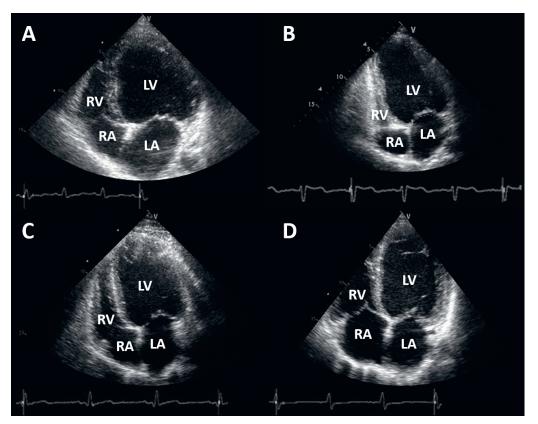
Apical four-chamber echocardiographic projections. Panel A and B - patient with LVRR (A - at baseline echo, showing grossly enlarged, thin-walled LV with severely impaired LV systolic function, EF - 22%; B - substantial decrease of LV cavity size alongside improvement of LV systolic function, EF - 42%). Panel C and D - patient without LVRR (C - baseline echo; D - lack of improvement of LV size and systolic function)
